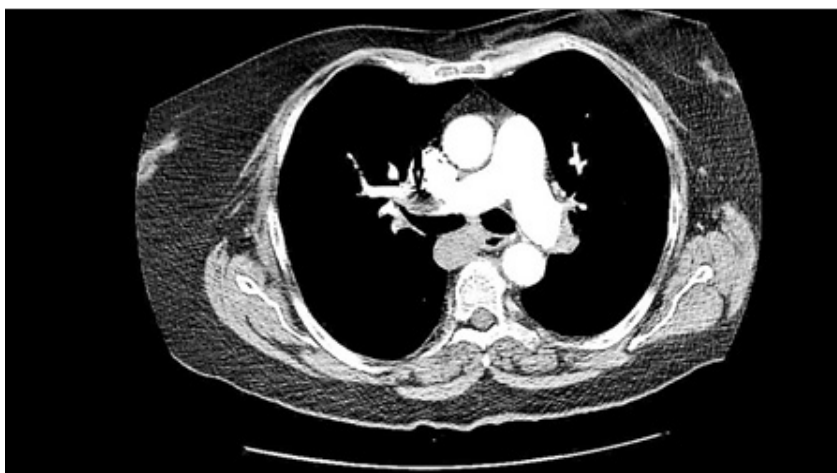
CT thoracic scan showing pulmonary embolism (black arrow).
